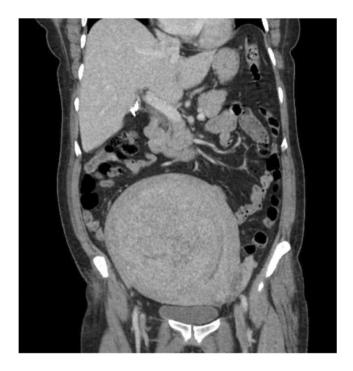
Coronal CT scan demonstrating an 18.1 cm heterogeneously enhancing thick-walled uterine mass with dilated ovarian veins.
